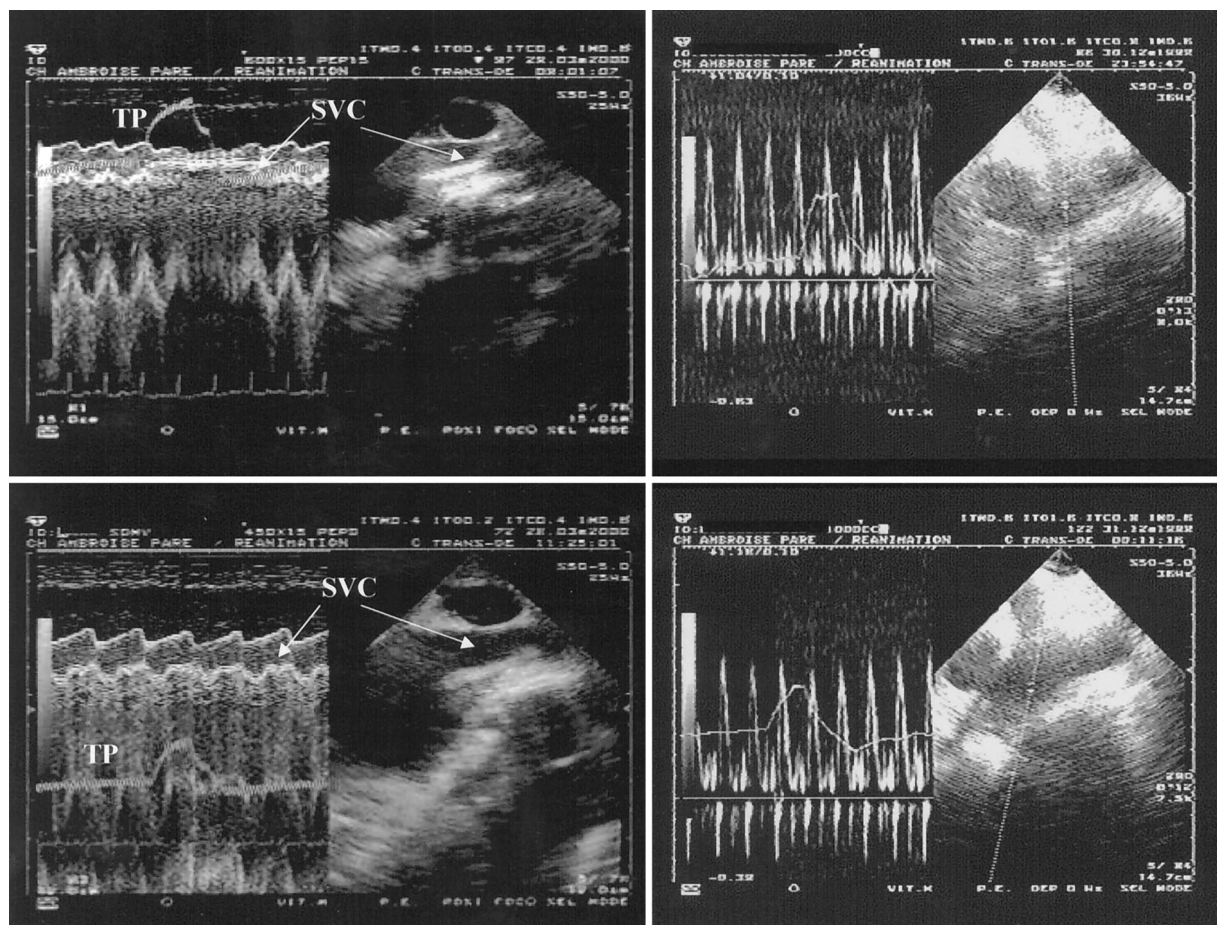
Example of the effect of a rapid volume expansion on superior vena caval (SVC) size and Doppler pulmonary artery flow velocity in a group 2 patient. At baseline (top), combined two-dimensional and M-mode echocardiography with simultaneous recording of tracheal pressure (TP) show a vena caval partial collapse (left) associated with a major inspiratory decrease in pulmonary artery flow velocity (right; group 2A). After volume expansion (bottom), only slight respiratory changes in SVC diameter and in pulmonary artery flow velocity persisted (group 2B).
